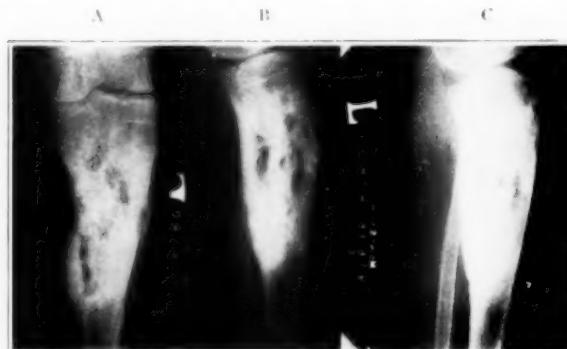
A-C. Roentgenograms of changes produced by short wave treatment in chronic osteomyelitis of left tibia, showing four discharging sinuses and calcification of muscles. Treatment with a 6 m. electromagnetic coil produced complete disappearance of calcified area and clinical improvement.
